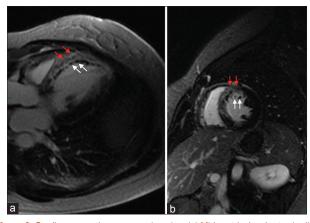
Cardiac magnetic resonance imaging, (a) Mid ventricular short axis slice demonstrating transmural infarct (red arrows) of the anterior septum with evidence of microvascular obstruction (white arrows) on delayed gadolinium. (b) Two-chambers view showing transmural infarction (red arrows) of the anterior septum with evidence of microvascular obstruction (white arrows) delayed gadolinium
